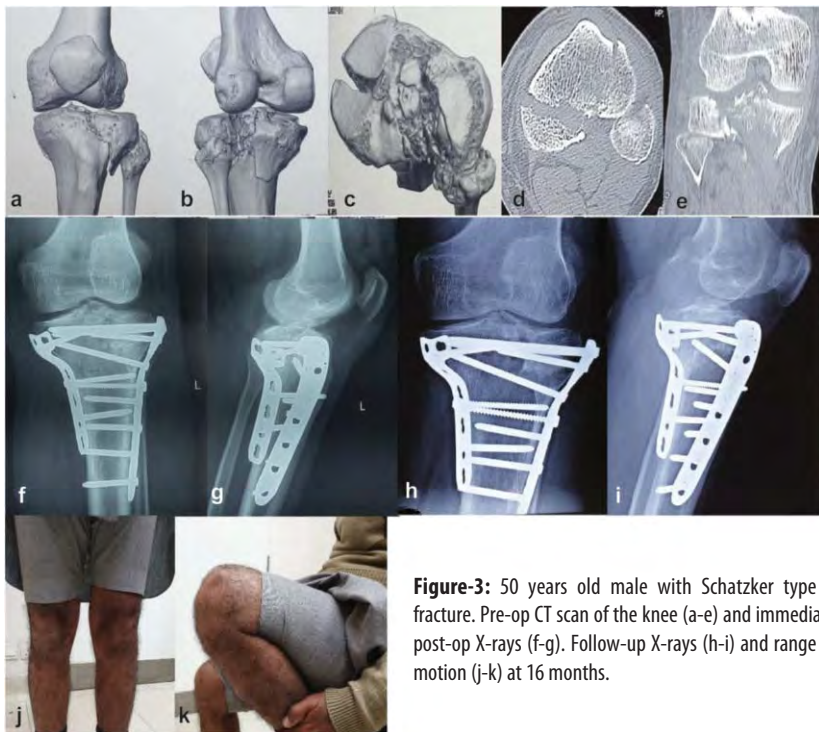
50 years old male with Schatzker type V fracture. Pre-op CT scan of the knee (a-e) and immediate post-op X-rays (f-g). Follow-up X-rays (h-i) and range of motion (j-k) at 16 months.
